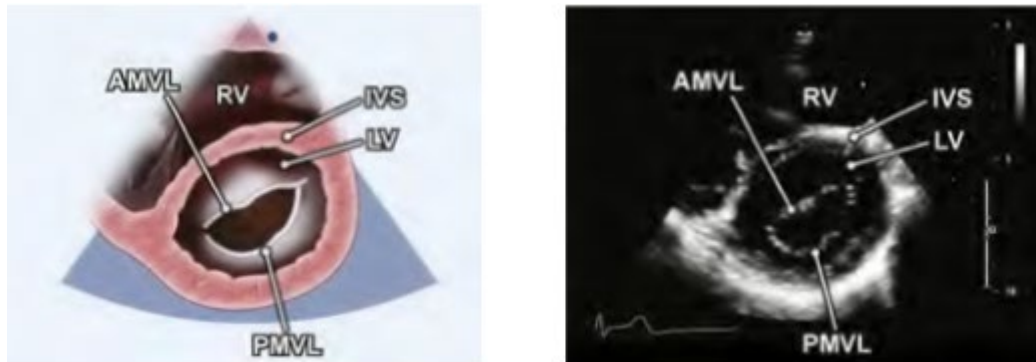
Parasternal short axis view of the left ventricle at the level of the mitral valve. Reproduced with permission from the American Society of Echocardiography. (135)
